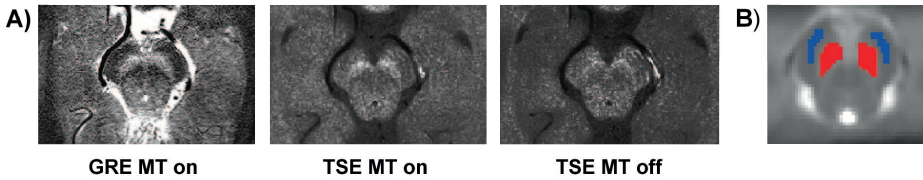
NM-MRI of the substantia nigra. (a) An individual example of the three NM-MRI sequences. (b) Manual segmentation of substantia nigra (SN) and crus cerebri (CC) mask on a standardized image in MNI space. The mask of the SN is shown in red and the mask of the CC in blue. GRE: gradient recalled echo; MT: magnetization transfer pulse; TSE: turbo spin echo.
